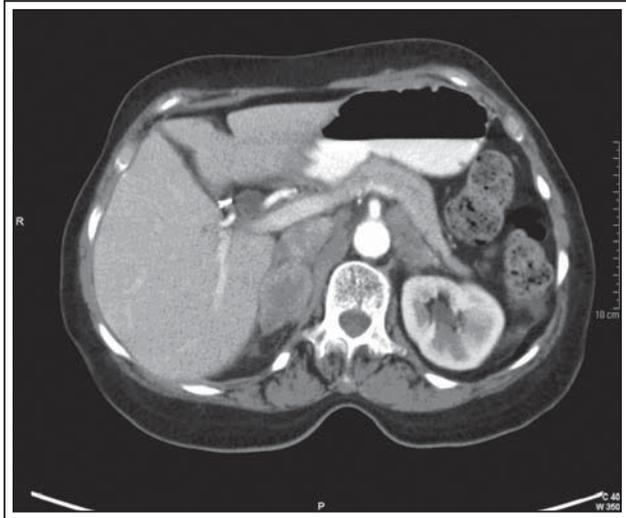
Abdominal CT with IV and PO contrast showing a 4.7 cm right adrenal mass.
